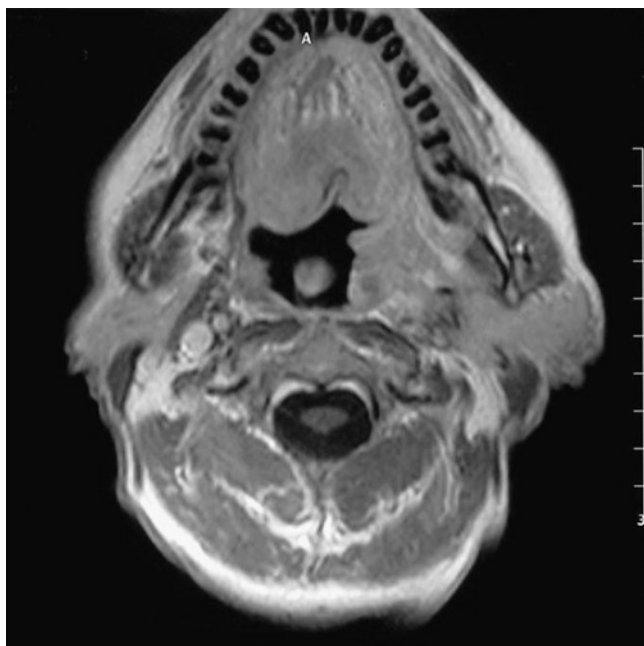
MRI of a patient with a T3N3 oropharyngeal carcinoma and encasement of the carotid artery
